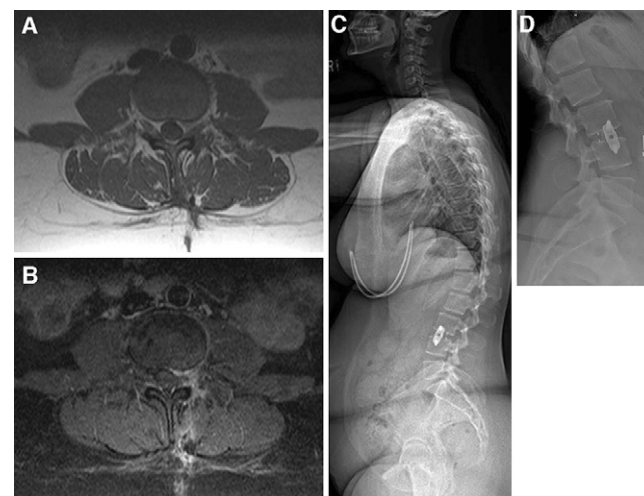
MRI demonstrating clinical course of patient in case 2, a 42-year-old female with extensive epidural fibrosis undergoing lateral lumbar interbody fusion. Axial T1 (A) and T1-weighted (B) images demonstrate presence of epidural fibrosis around lateral recess with extension along the exiting nerve root on the left. C: Lateral standing radiograph demonstrates interbody cage at L3–4. D: Lateral standing radiograph at 1-year follow-up demonstrating stable construct, stable spinal alignment, no hardware failure, and evidence of arthrodesis.
